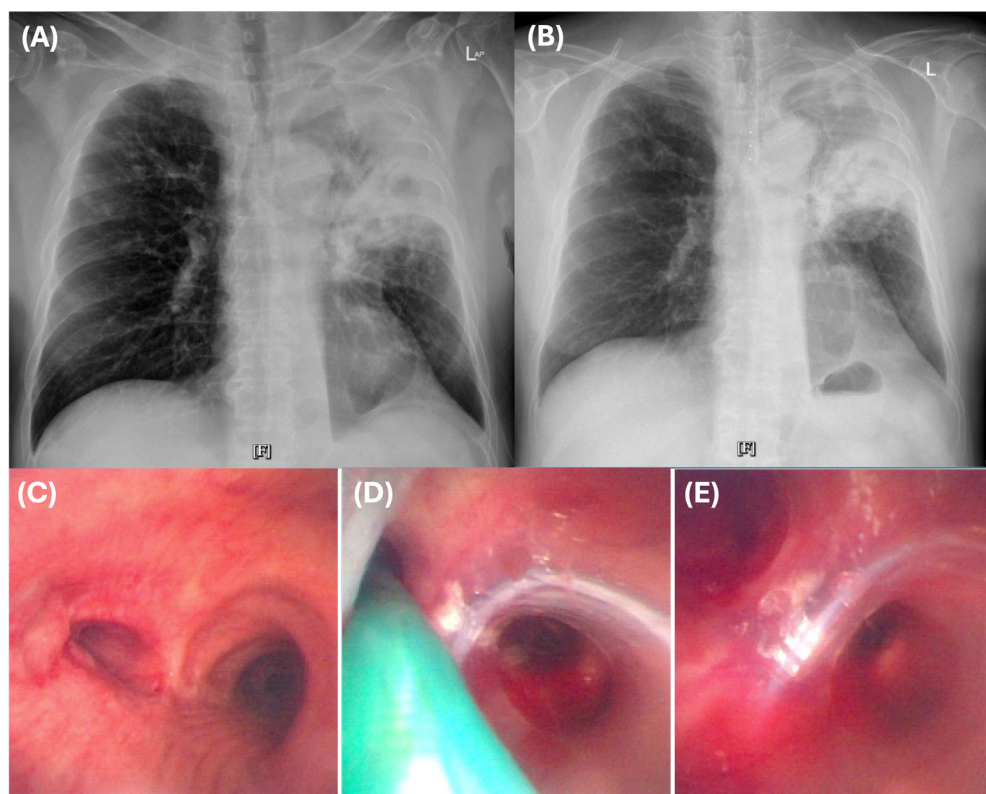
Radiologic and bronchoscopic findings before and after airway stenting in Case 2. (A) Pre-procedural chest radiograph showing heterogeneous opacity in the left lung field, suggestive of airway obstruction with associated parenchymal changes. (B) Post-stenting chest radiograph demonstrating interval stabilization of lung aeration, with visualization of the airway stent along the tracheobronchial axis. (C) Pre-intervention bronchoscopy showing significant luminal narrowing consistent with tracheobronchial stenosis. (D) Intra-procedural view during stent deployment, with the delivery system in place and partial restoration of the airway lumen. (E) Post-stenting bronchoscopy demonstrating improved airway patency, with the stent in situ and adequate luminal expansion.
